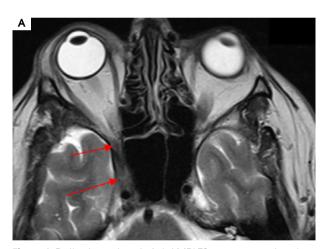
Patient number 6. Axial MRI T2 sequences showing asymmetrical thickening up to 6 mm within the right cavernous sinus, laterally directed towards the superior orbital fissure and the top of the orbit
